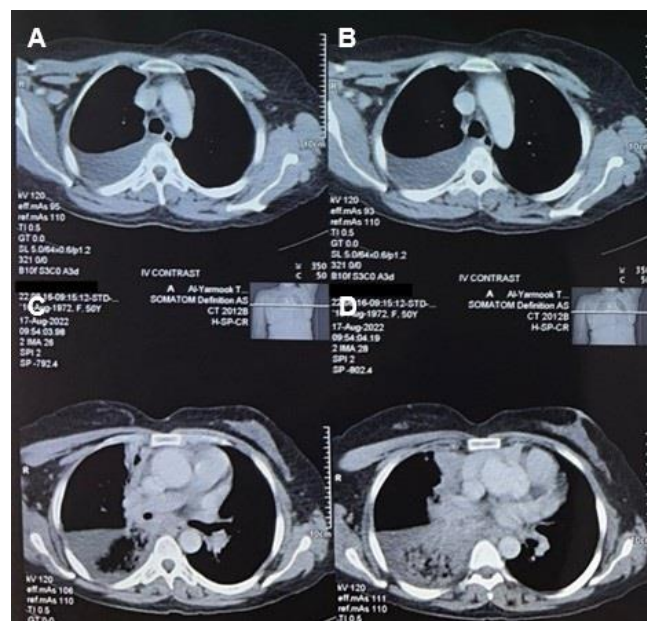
chest CT scan findings. Chest CT scan with IV contrast displaying distinct aspects of the patient's condition: A and B: Moderate right-sided pleural effusion. C: Total occlusion of the bronchus intermedius along with complete collapse of the right middle lobe. D: Interlobular septal thickening in the right upper lobe, accompanied by partial collapse of the right lower lobe, revealing extensive fibrotic changes.
